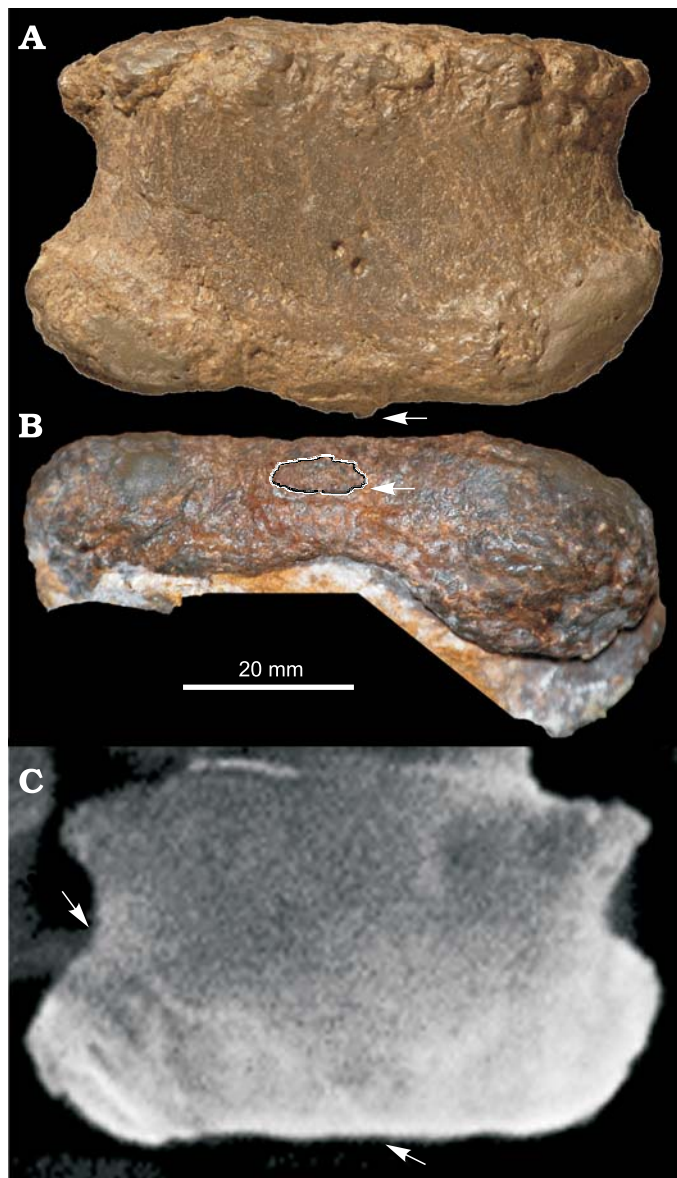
Overgrowth type 3 (arrows in A, B) on the distal articular surface of the left manual phalanx IV-1 of the camarasaurid sauropod SMA 0002 from Upper Jurassic Morrison Formation, Howe-Stephens Quarry, Wyoming, USA; in anterior/dorsal (A) and distal (B) views, and CT scan of frontal slice (C), note the probable healed fracture (arrows). Photos taken by Rosemarie Roth (University of Zurich, Switzerland).
